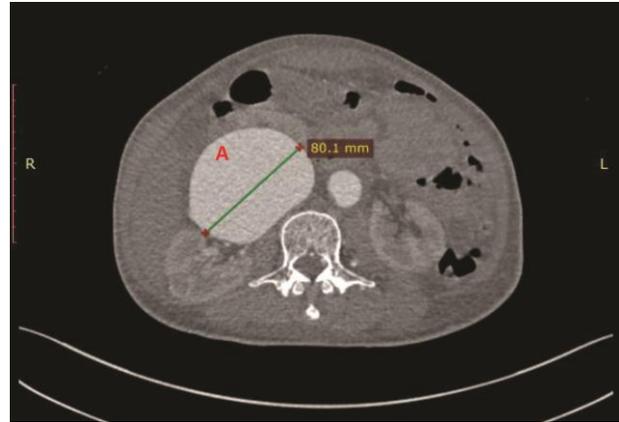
Axial contrast enhanced CT scan showing the aneurysmally dilated and tortuous inferior vena cava (A) with focal and fusiform ectasia involving 11.4 cm of its length at the infrarenal level; maximal diameters of 8 x 6.6 cm (W x AP).
